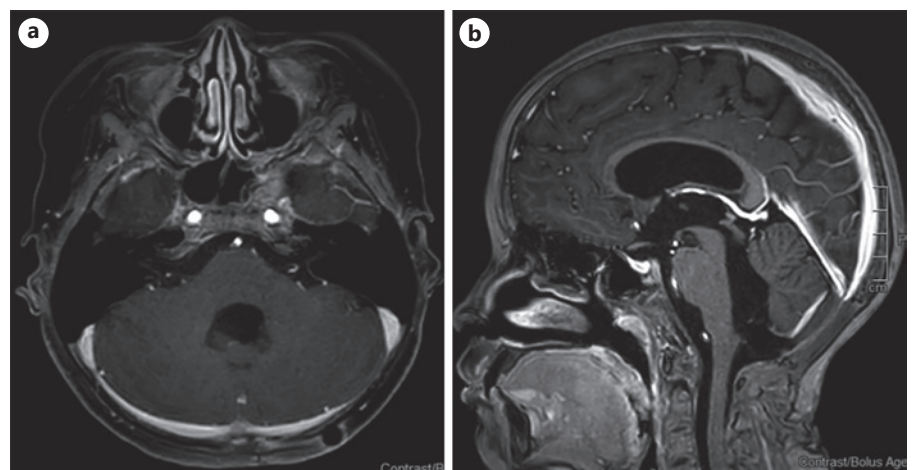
Gadolinium-enhanced axial (a)/sagittal (b) T1-weighted images of the patient after completion of radiotherapy and chemotherapy showing stable condition 2 years after surgery.
